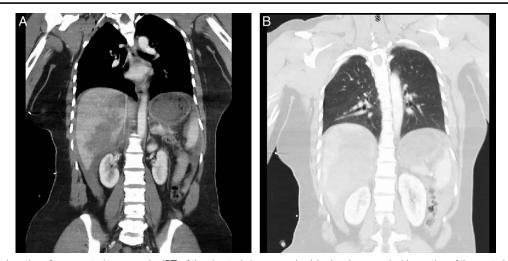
(A) Coronal section of a computed tomography (CT) of the chest, abdomen, and pelvis showing a grade 4 laceration of the posterior aspect of the right lobe of the liver with active extravasation seen along the posterior aspect of the liver. There is free perihepatic fluid, free perisplenic fluid, and moderate fluid in the pelvis. (B) Coronal section of a CT of the chest, abdomen, and pelvis showing a small right pneumothorax and fractures of the right first, second, fourth, fifth and sixth ribs.
